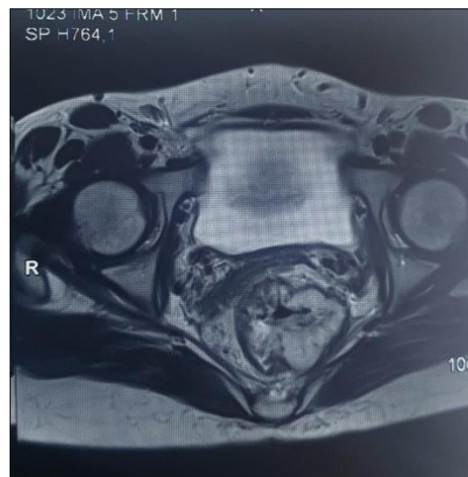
pelvic MRI showing a large tumor localized in the lower and middle rectum, with infiltration of adjacent tissues
